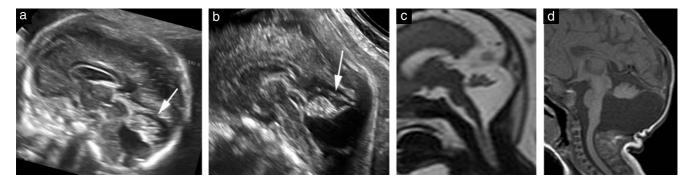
Imaging in a patient referred at 20 weeks' gestation. The transvaginal fetal sonogram (a) demonstrated moderate elevation of the cerebellar vermis but the cisterna magna was not felt to be enlarged and the downslanting tentorium (arrow) suggested a normal position of the torcular. At 25 weeks (b) the cisterna magna had increased in size, the rotation of the vermis was increased and the angle formed by the tentorium (arrow) suggested upward displacement of the torcular. At this time, a diagnosis of Dandy–Walker malformation was made and this was confirmed by prenatal (c) as well as postnatal (d) magnetic resonance imaging.
